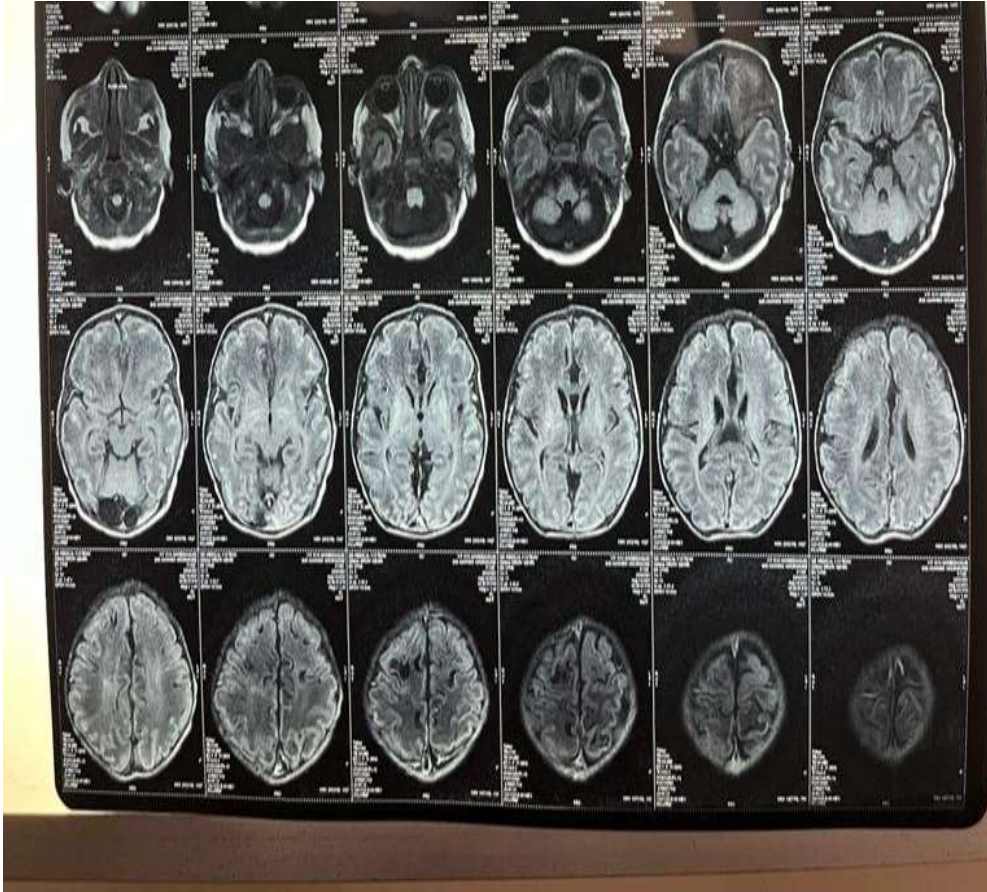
MRI of Brain showing hypoxic ischaemic encephalopathy changes
